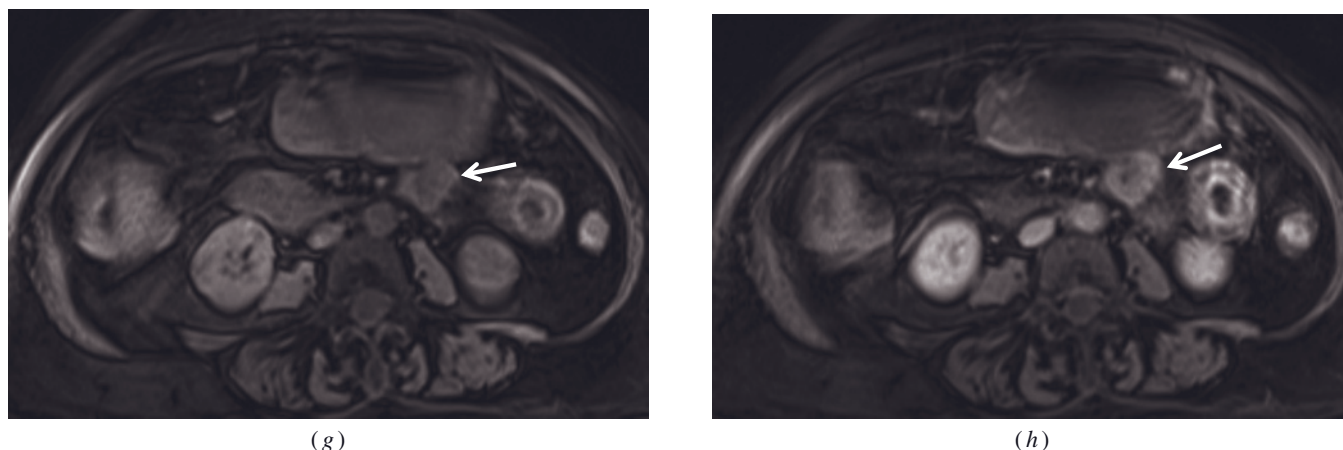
(Continued) 3D-GE (g), and T1-weighted postgadolinium interstitial phase fat-suppressed 3D-GE (h) images demonstrate a small neuroendocrine tumor (arrows, e–h) located in the mesentery adjacent to the jejunum. The tumor shows heterogeneous signal on T2-weighted images (e, f) and enhances moderately on the interstitial phase (b). Multiple liver metastases and ascites are detected. Note that the wall of the jejunal segment adjacent to the tumor shows edema and moderate enhancement.
